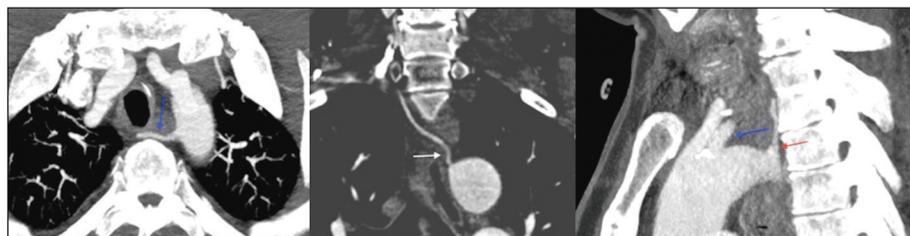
Computed tomography angiography shows the right vertebral artery distal to left subclavian artery and retroesophageal-tracheal course. A) Axial. B) Coronal. C) Sagittal curved reformed maximum intensity projection (MIP) images.
